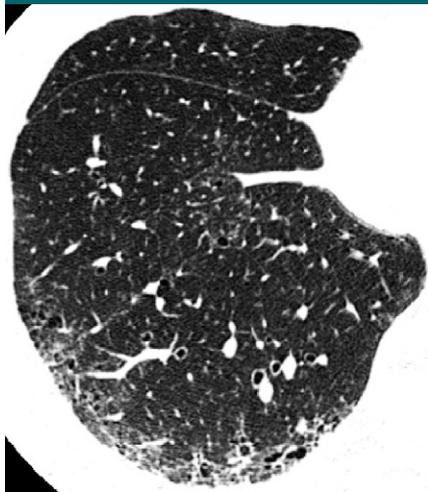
Possible UIP pattern in a 53-year-old man. Transverse thin-section (0.5-mm) CT image through the right lower lobe shows intralobular reticular opacity, ground-glass opacity with traction bronchiectasis, and microcysts in a predominantly peripheral distribution. Pathologic diagnosis of UIP was made.
